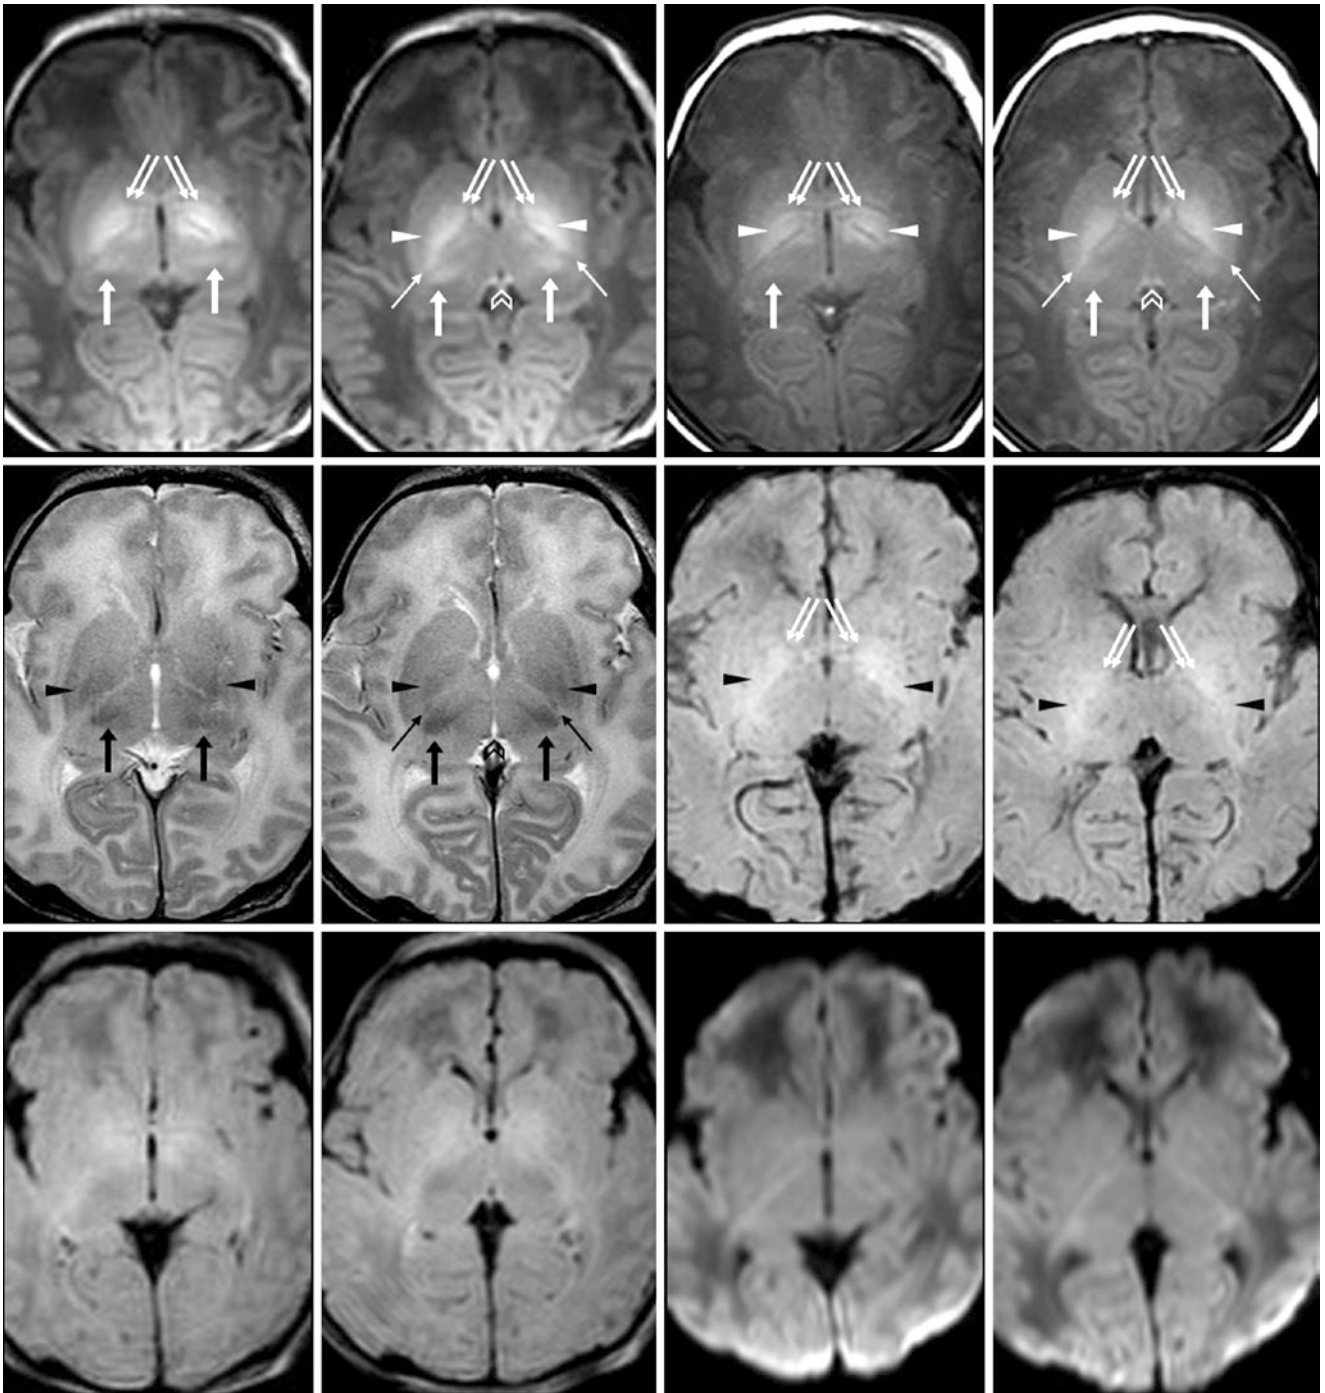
A 1-day-old term neonate with a solitary seizure and a normal 3T MRI. *Top row:* Spoiled GE T1WI (*left*) and SE T1WI (*right*) both show bright signal of the globi pallidi (GP) (*double arrows*) and posterior putamina (PP) (*arrowheads*)—that is, of the lentiform nuclei (LN)—and the ventrolateral thalami (VLT) (*arrows*), being brighter on GE T1WI. The PLIC (*thin arrows*) is also bright, although its proximity to the PP makes it difficult to discern. Note the bright habenular commissure (*chevrons*). Such normal structures usually appear brighter on
